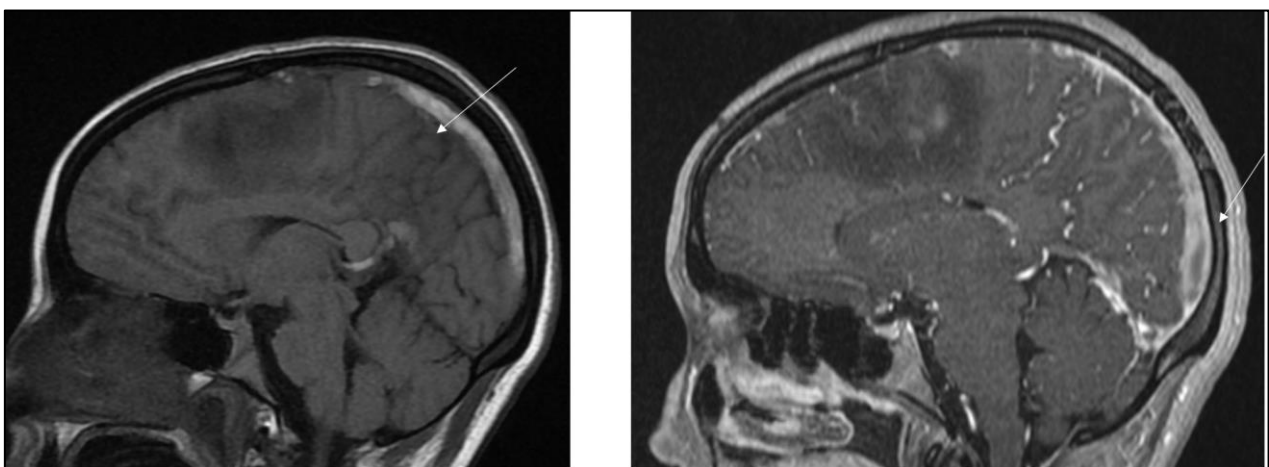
T1 brain MRI: Presence of a T1 hypersignal content in the superior longitudinal sinus, corresponding after injection to an extensive thrombus of the superior longitudinal sinus (arrows)
